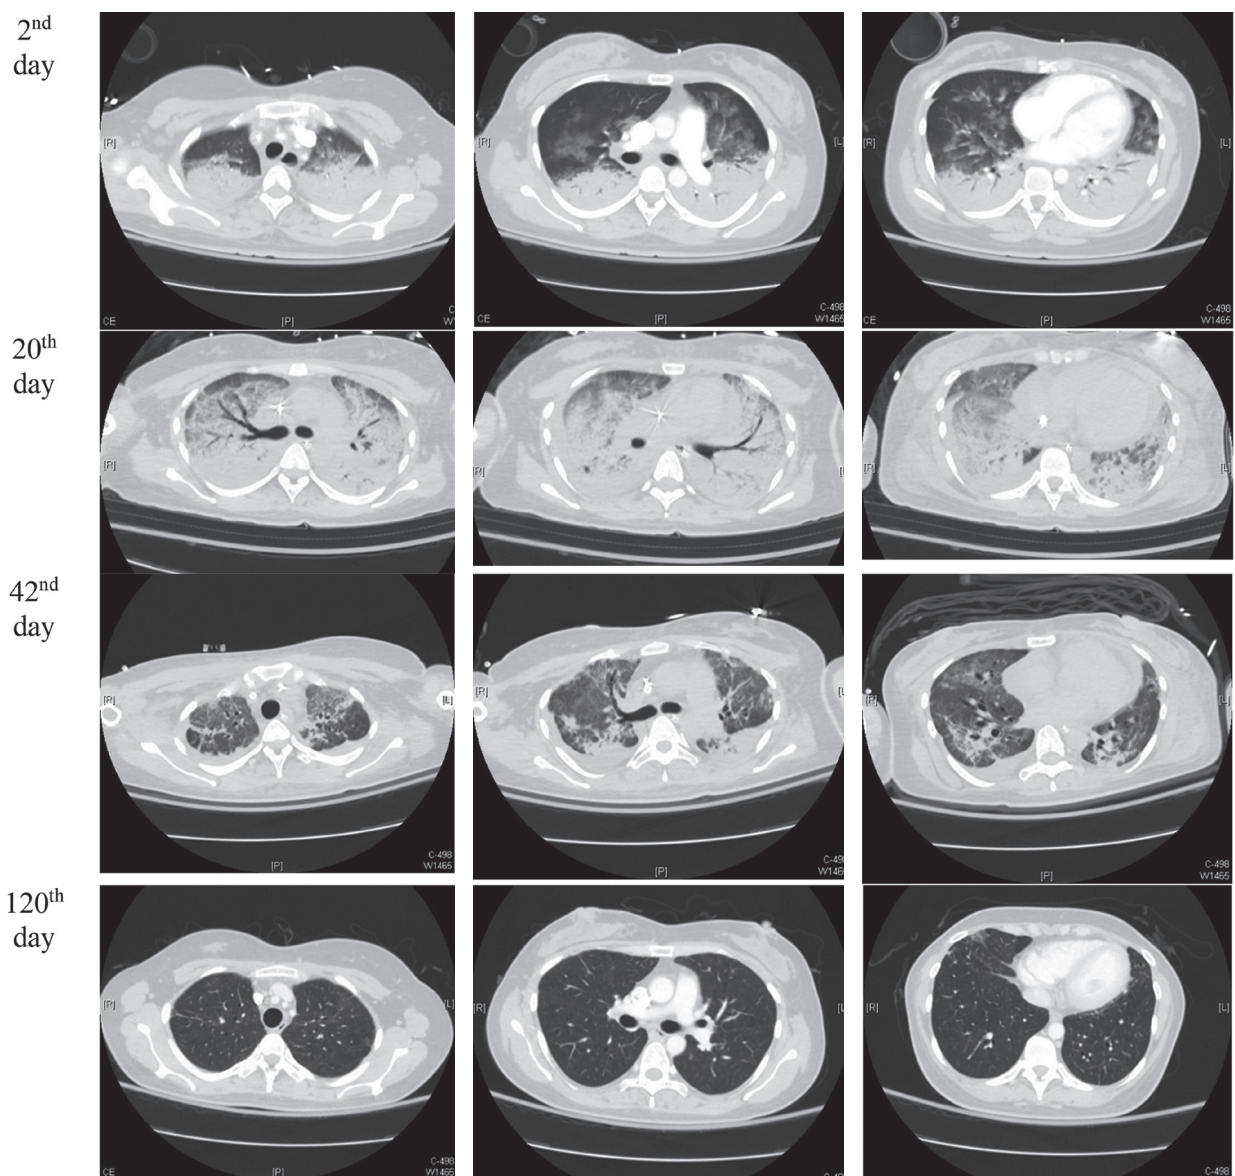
Chest computed tomography.
